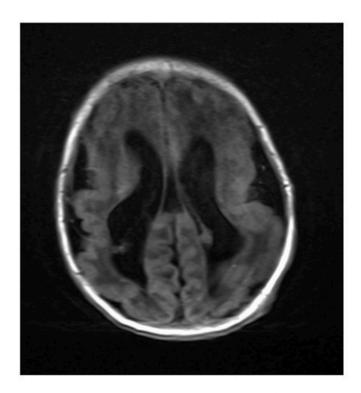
Cranial magnetic resonance imaging findings.
